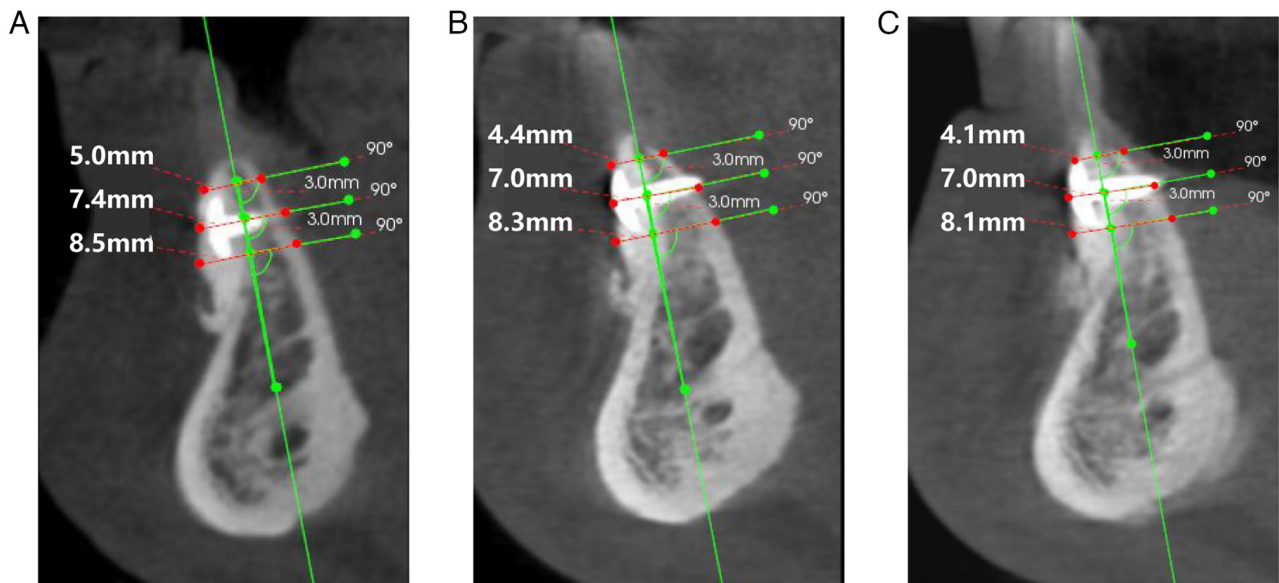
Bone width assessment by cone-beam computed tomography after augmentation surgery. (A) Immediately, (B) 6 months and (C) 10 months after the surgery.
